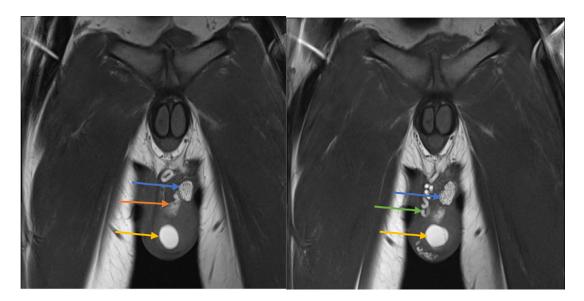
MRI T1-weighted images (coronal cut) showing dilated left testicular mediastinal tubules representing tubular ectasia of rete testis (orange arrow), along with enlargement of the left epididymis with multiple cystic interfaces (blue arrow) and dilated tortuous left ductus deferens along the medial side of epididymis posterior to the testis (green arrow); all of these structures elicit T1-hyperintense signal suggestive of proteinaceous/hemorrhagic contents. A well-defined rounded lesion (hematoma) can be seen at the inferior pole of the left testis (yellow arrow).
